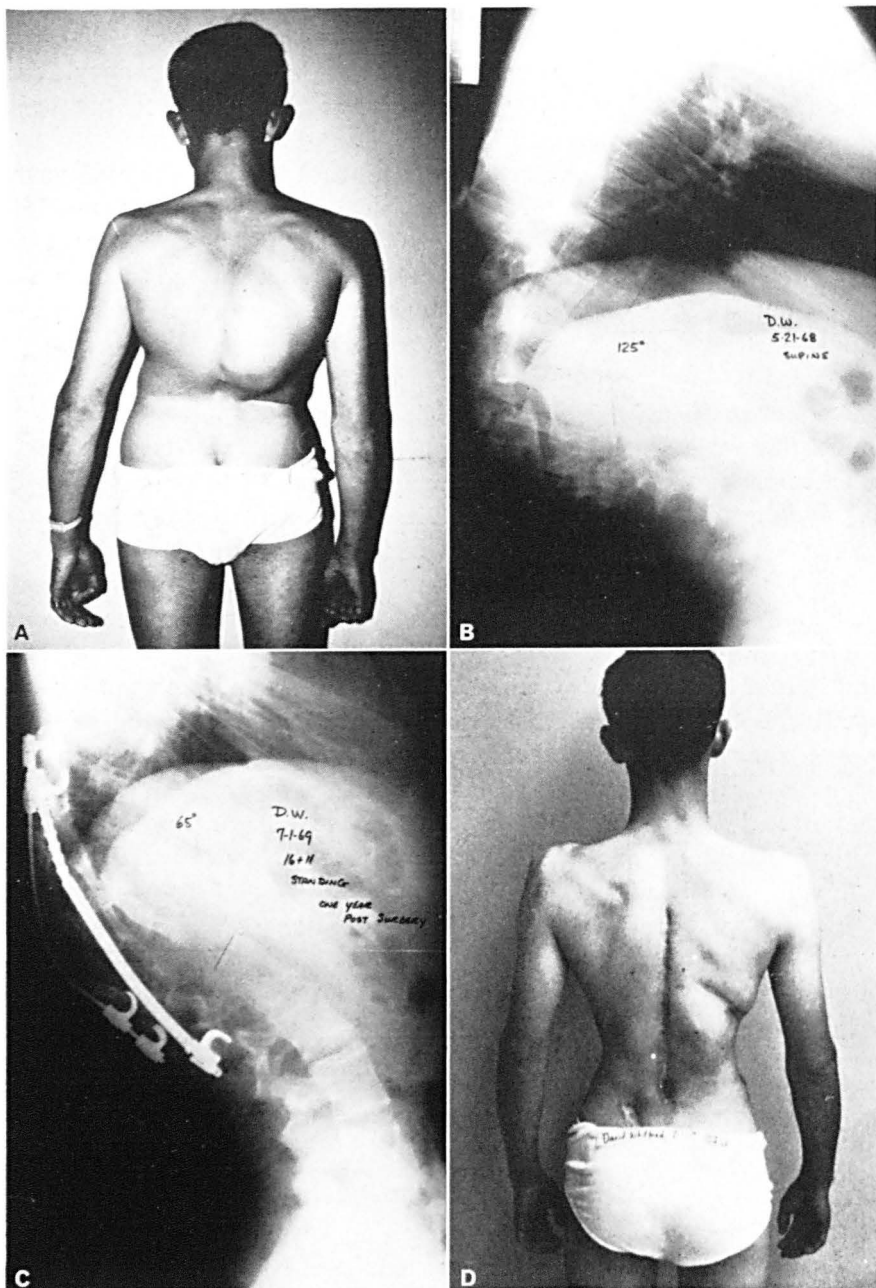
A. D.W. A 15-year-old male with congenital kyphosis, back view (patient of Dr. Moe's). B. Lateral supine x-ray, kyphosis 125°. C. Lateral standing x-ray 1 year after surgery (anterior release, osteotomy, sib grafting Harrington instrumentation and halo cast). D. Posterior view 1 year later.
